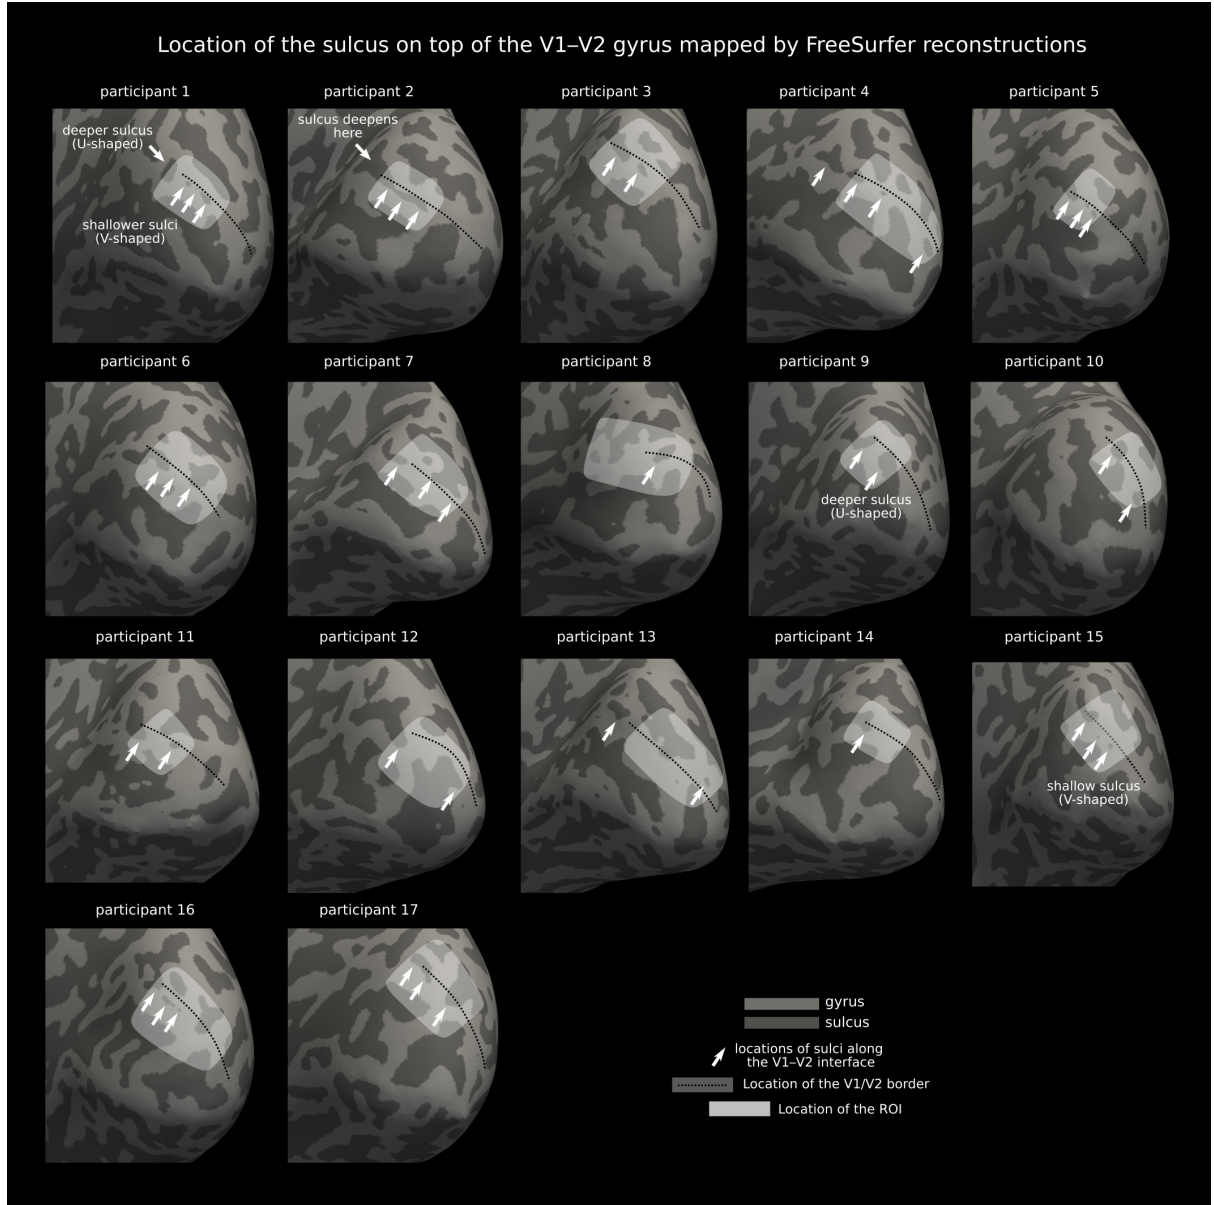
Localisation of the shallow sulcus (ISGS) on the crown of the V1–V2 gyrus in all participants. The sulcus could be identified within the ROI (highlighted region) in all individuals on reconstructed curvature maps (threshold at 0 curvature) shown here on inflated cortical surfaces. The sizes, shapes and spatial distributions of the sulcus (white arrows) varied in the ROI across individuals and within each individual along the eccentricity direction. Both deep and shallow sulci were observed (see example for participant 1). For participants 1, 4, 16 and especially 2 the mapped sulcus was almost continuous in the eccentricity direction. Because the curvature of the sulcus was likely small relative to the 0.7 mm isotropic MP2RAGE spatial resolution it is possible that FreeSurfer reconstructions could not map it at all locations along the V1–V2 gyrus. This possibly explains the non-flat bending angles of SAF (mean \pm standard deviation $152 \pm 15^\circ$) mapped in locations where the sulcus could not be detected (i.e. flat curvature). Higher resolution MRI is required to further investigate the existence and appearance of the sulcus, as well as its relationship with SAF geometry.
